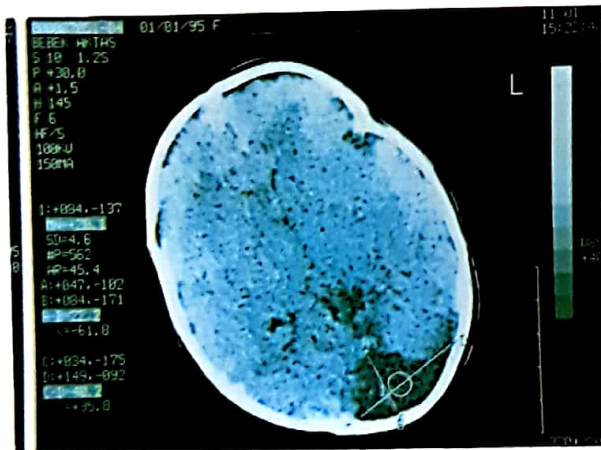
Computed tomographic images show enlarged fourth ventricle and hypoplastic cerebellar hemispheres. The cerebellar vermis is absent.
